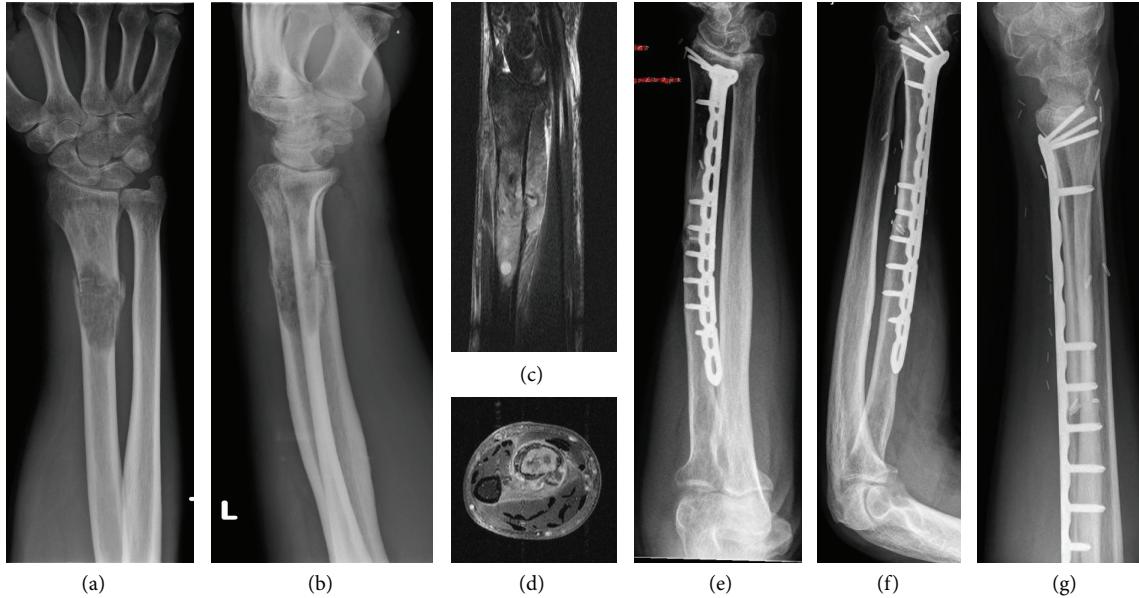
(a–g). Preoperative X-ray (a–b) and MRI (c–d) of a 64-year-old patient with osteosarcoma of the left distal radius; X-ray 22 months after replacement with allograft (e–g).
